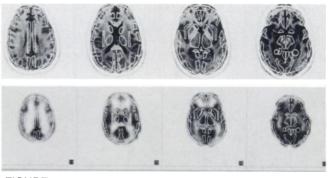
Adjusted template regions overlaid upon MRI (top) and corresponding PET (bottom) slices.
